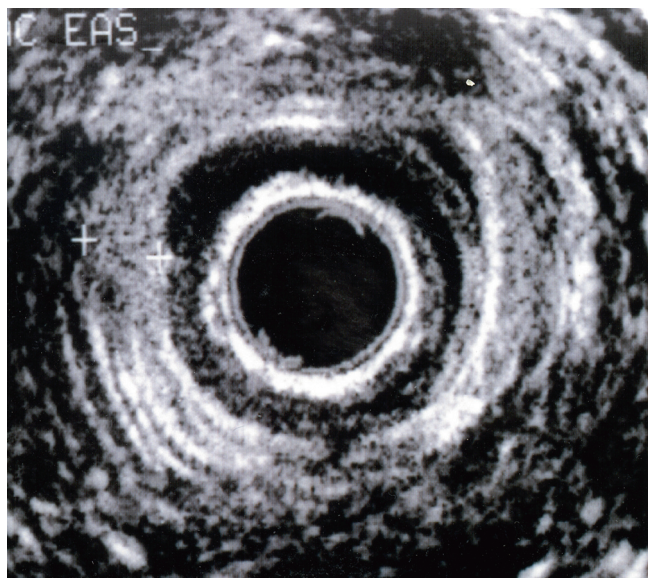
Endoanal ultrasound of prefecal incontinence without obvious defects.
